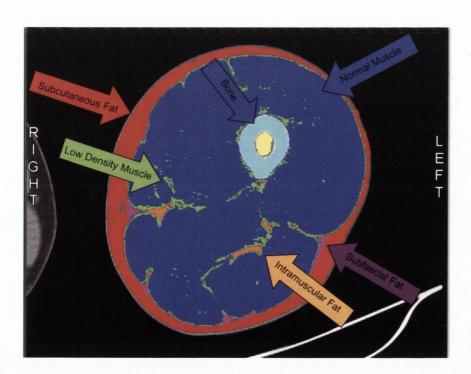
Typical SlicOmatic CT image depicting composition of mid-thigh
